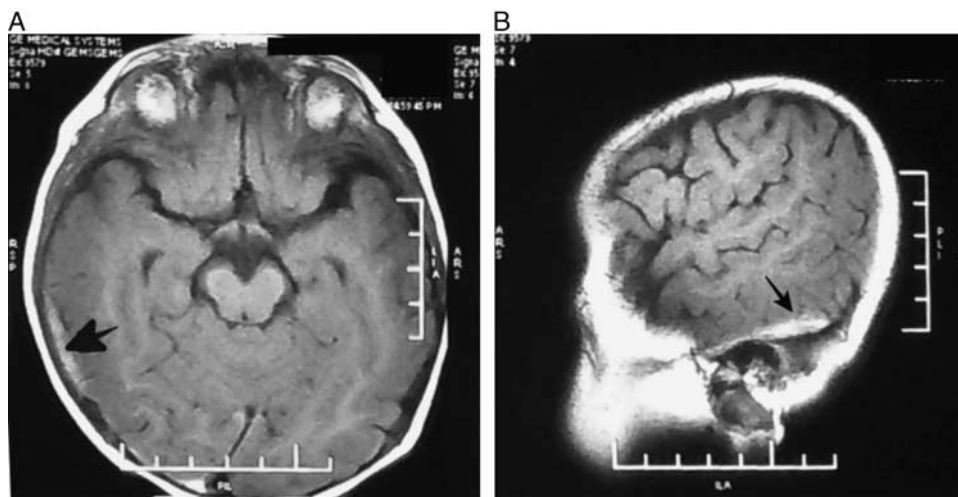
MRI brain. T2 fluid attenuated inversion recovery axial (A) and sagittal (B) images show subdural hematoma over right temporo-parietal lobes and along the right leaf of tentorium (marked by arrows).
